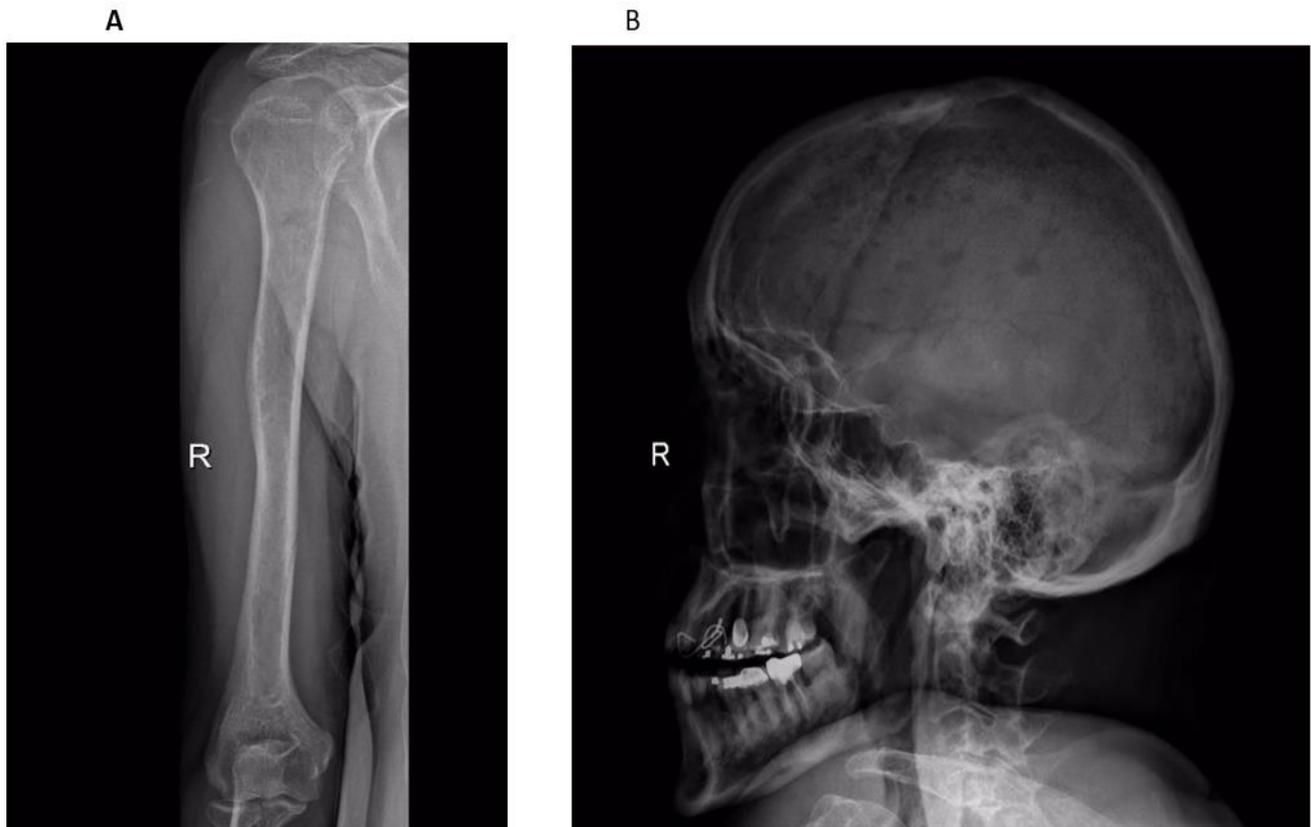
Patient 2 frontal chest radiography (A) and lateral skull (B) radiograph showing representative lytic lesions in humerus and disseminated raindrop skull lytic lesions. Images were obtained at admission to myeloma clinic.
